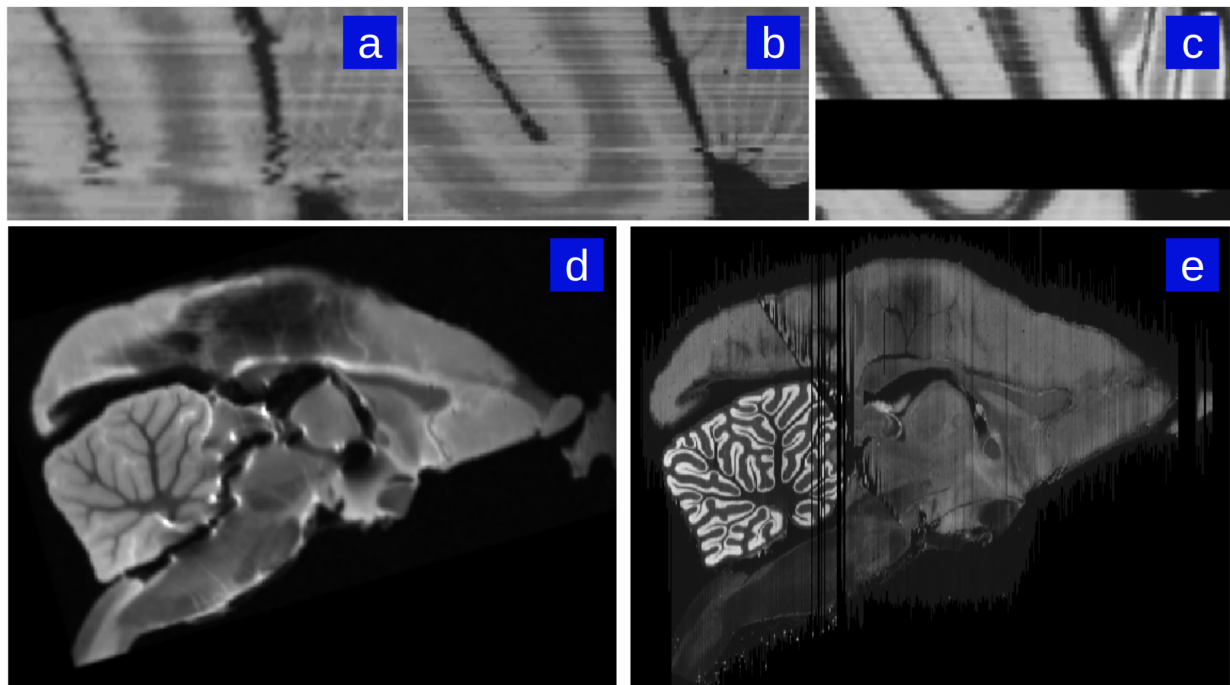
Reconstruction examples depicting the effect of the smoothness prior. When the Nissl stack (c) has missing or noisy sections, reconstruction to the next-best Nissl section contains small distortion accumulations (a). Inclusion of a smoothness constraint corrects this error (b). Additionally, highly damaged Nissl stacks can still be reconstructed despite major differences between damaged Nissl sections to corresponding MRI sections. For instance, ex-vivo MRI of a particular subject marmoset brain prior to sectioning (d) and successful Nissl reconstruction of the same marmoset brain despite major damage caused by sectioning process (e).
